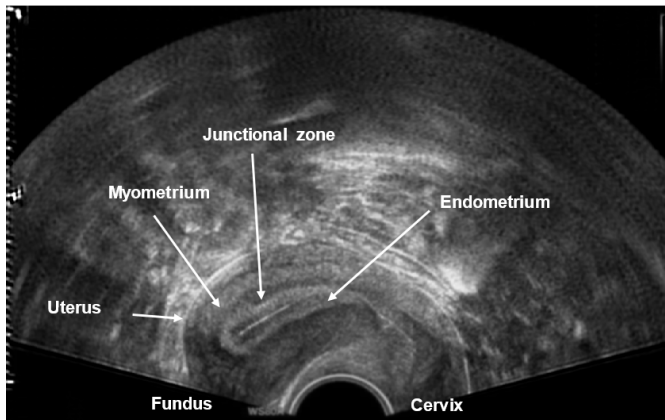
Example of acquired ultrasound (US) frame from an *in vivo* recording during the late follicular (LF) phase.
